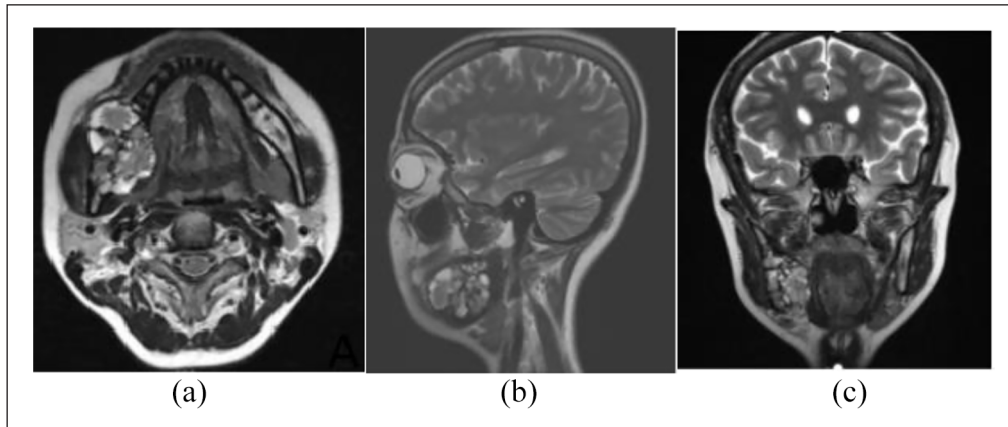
Extensive ameloblastic carcinoma originating from the right mandible, T2 weighted MRI: (a) axial view, (b) sagittal view, and (c) coronal view.
